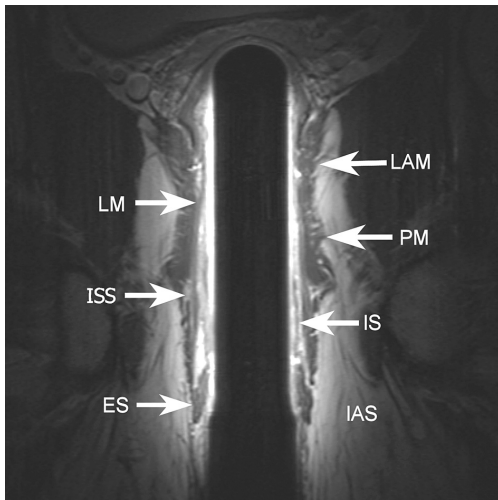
Coronal endoanal T2- weighted fast spin-echo (2500/70) MR image through the anal canal shows normal anatomy of the sphincter complex in a 52-years-old man with relative hypointense external anal sphincter (ES) and relative hyperintense internal anal sphincter (IS). IAS = ischioanal space, LM = longitudinal muscle, ISS = inter sphincteric space, PM = puborectal muscle, LAM = levator ani muscle
